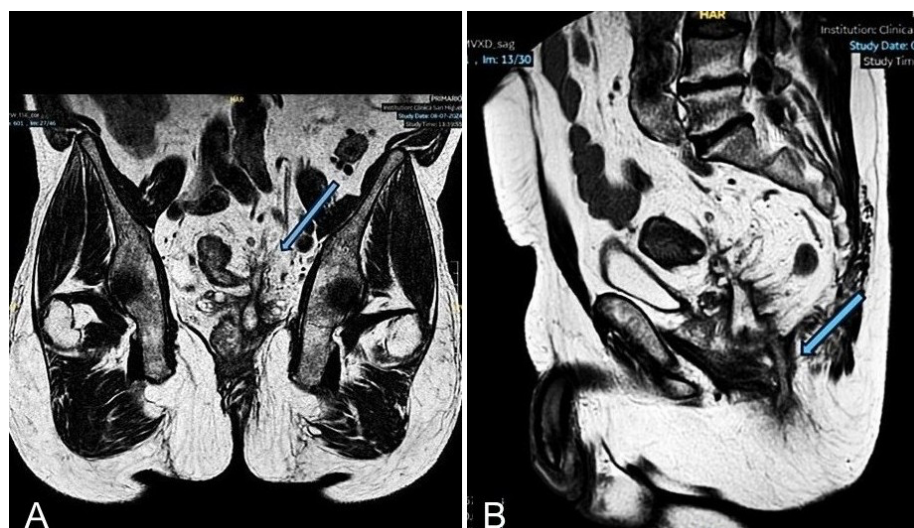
Pelvic MRI demonstrating a perianal fistula secondary to complicated acute sigmoid diverticulitis. A. Coronal image: the pelvic origin of the fistulous tract is identified (arrow), with a small associated fluid collection. B. Sagittal image: the fistulous tract extends through the levator ani muscle and reaches the ischioanal fossa (arrow).
